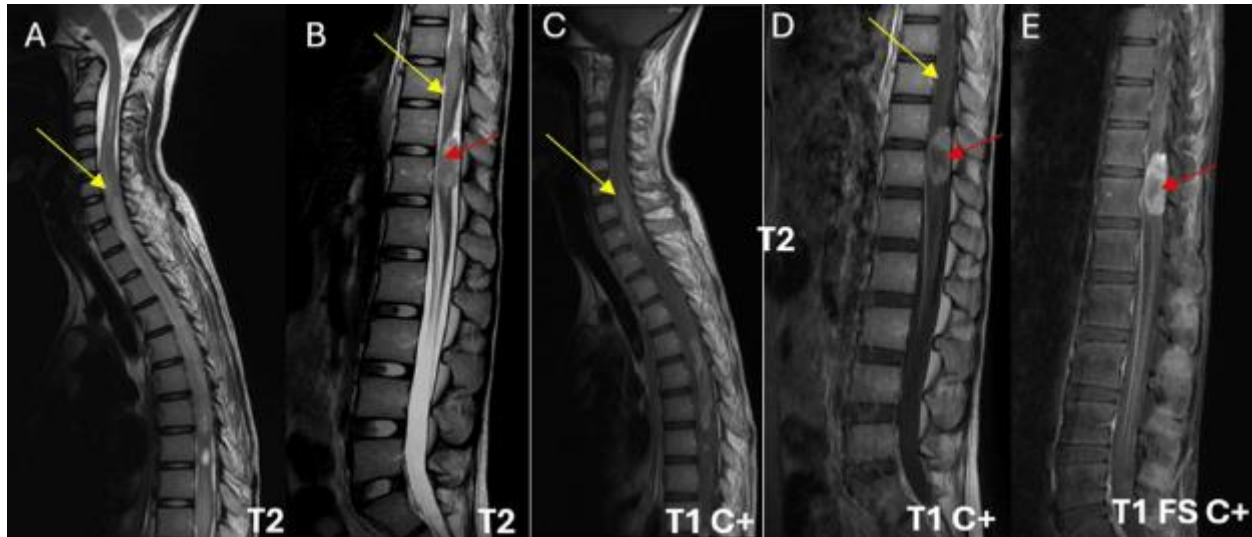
Follow-up cervico-dorso-lumbar MRI
